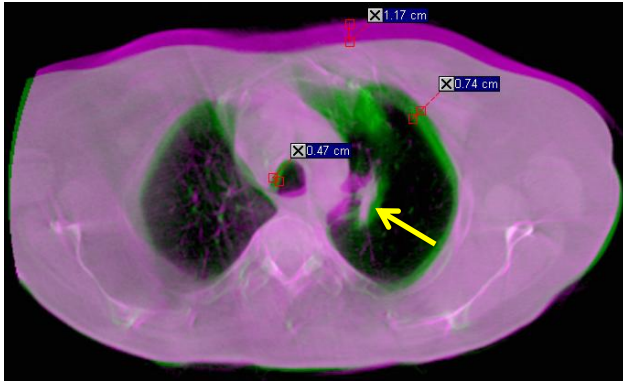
A correctly (green) and erroneously (violet, Figure 16B) acquired DIBH CBCT image for patient 13 at fx 33 overlaid on each other. The arrow indicates the tumor location. The color shifts are measures on how much the anatomy is shifted in the patient. The anterior surface shift (violet) corresponds to the baseline shift in Figure 16B.
